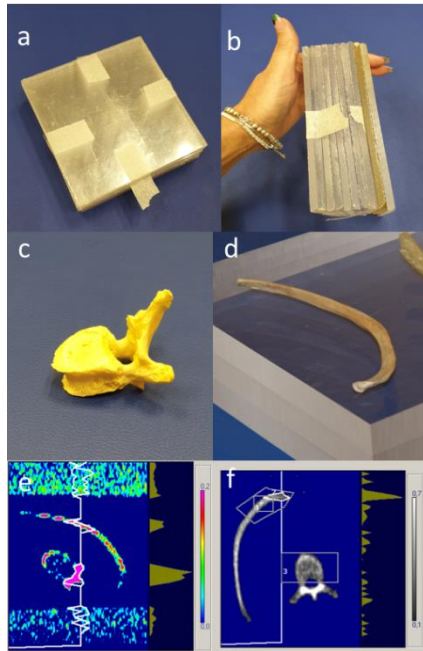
Image of plexiglass sheets used for the experiments (a, b), human vertebra and rib used for experiments (c, d) and images resulted during the experiments (e) and after the final DXA experiment with the optimal setting of support material, its thickness and distance from X-ray beam (f).
